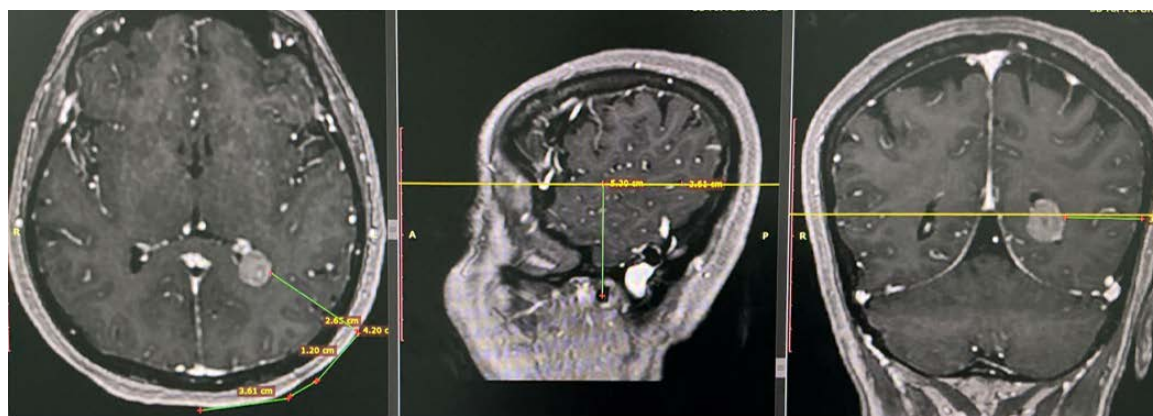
On contrast-enhanced magnetic resonance imaging (MRI), an iso- to hyperintense, homogeneous, well-circumscribed, round lesion is observed, located intraventricularly at the level of the left atrium.)
